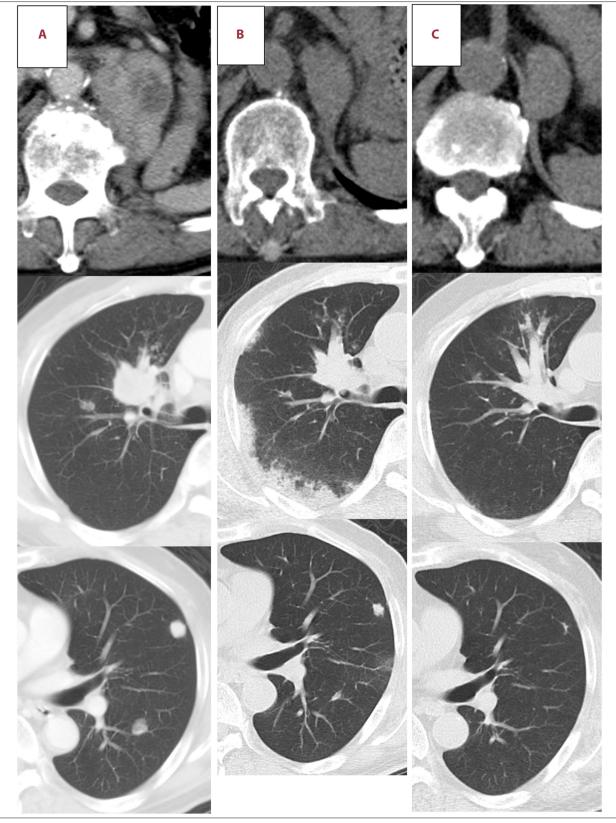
The CT scan shows left adrenal and lung metastases before initial nivolumab therapy (A), after 3 cycles of nivolumab therapy (B), and 7 months after nivolumab discontinuation (C).
